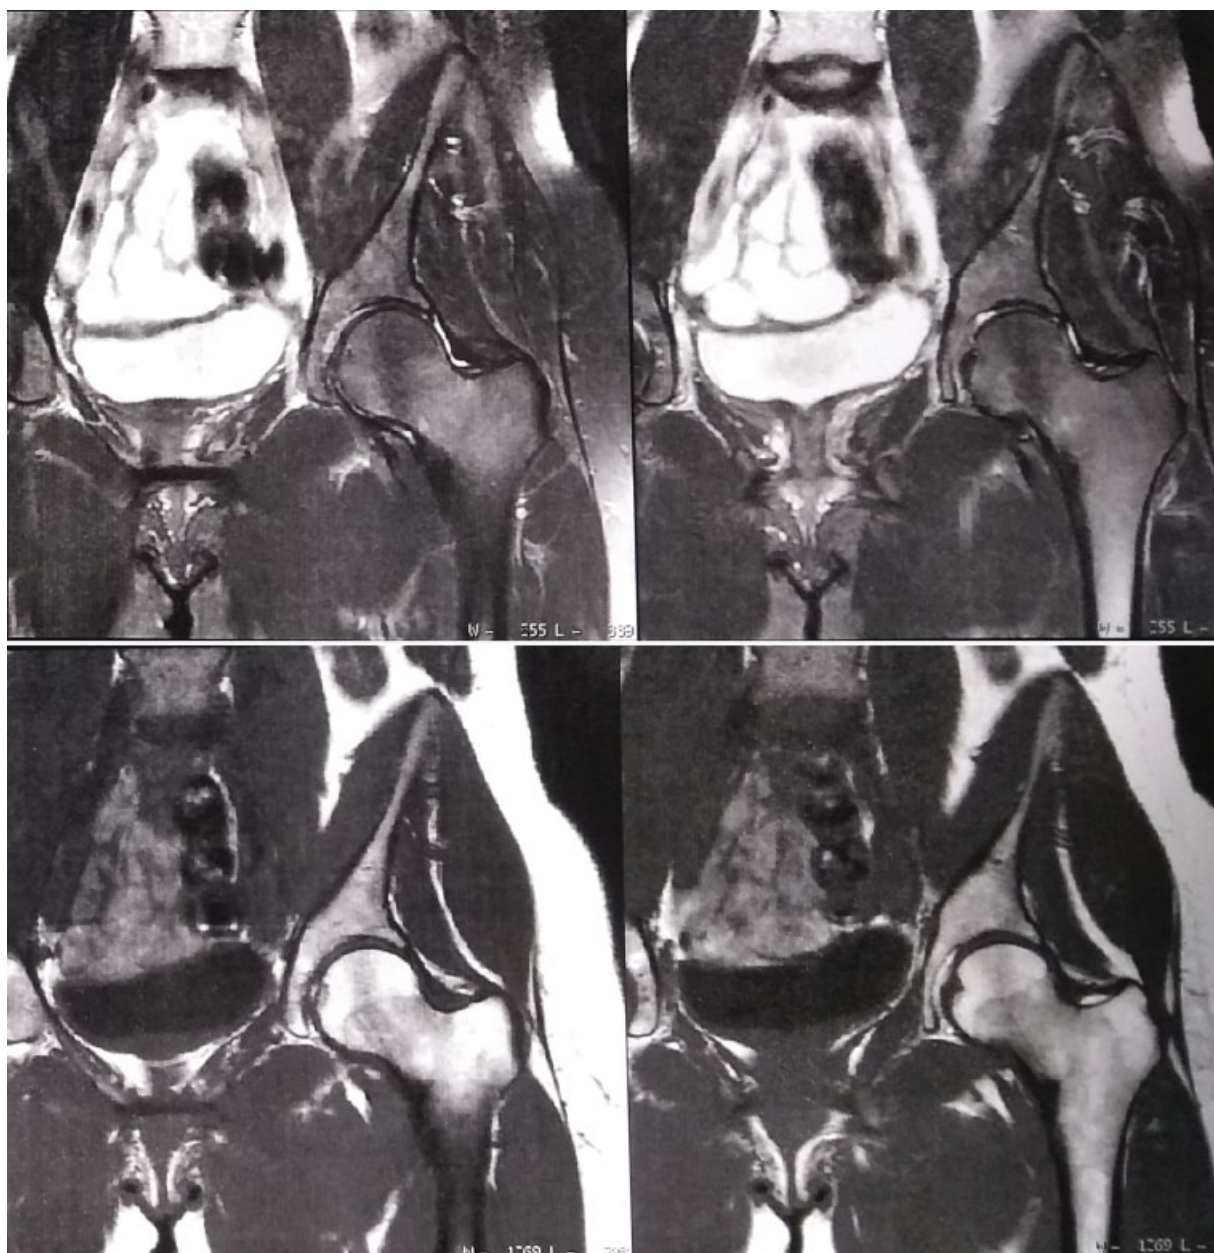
T2-weighted magnetic resonance imaging scan confirming femoral neck fracture consolidation.
